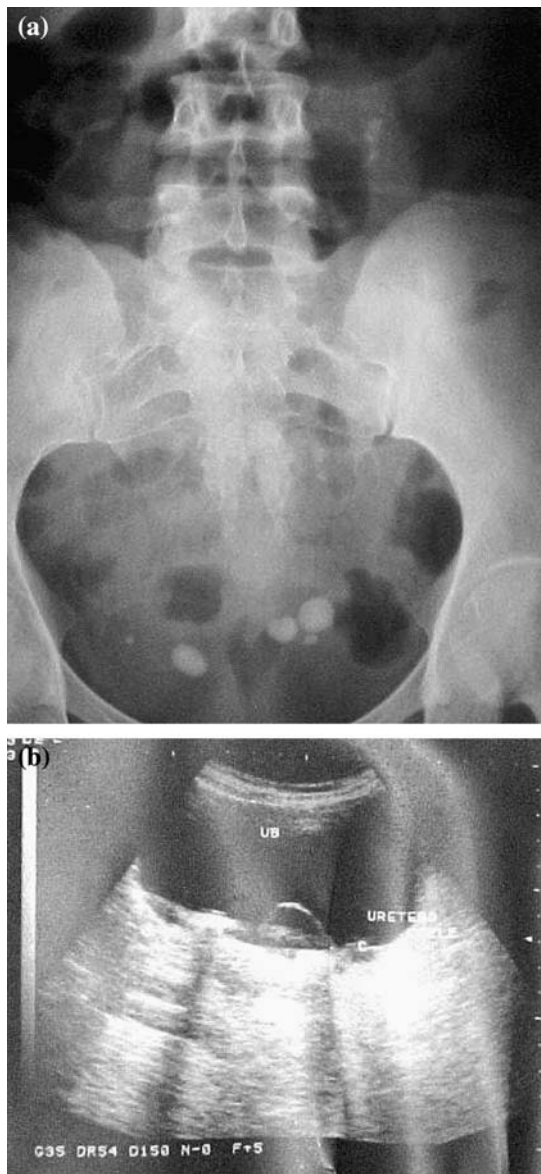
X-ray KUB showing the bilateral radiopaque densities suggestive of lower multiple ureteral calculi (a) and the ultrasound showing bilateral intravesical orthotopic ureteroceles (b)
